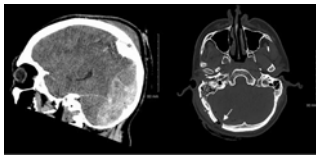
CT scans from case 1 showing the large left temporal extradural haematoma and the position of the Burr hole (arrow) drilled in the emergency department.
